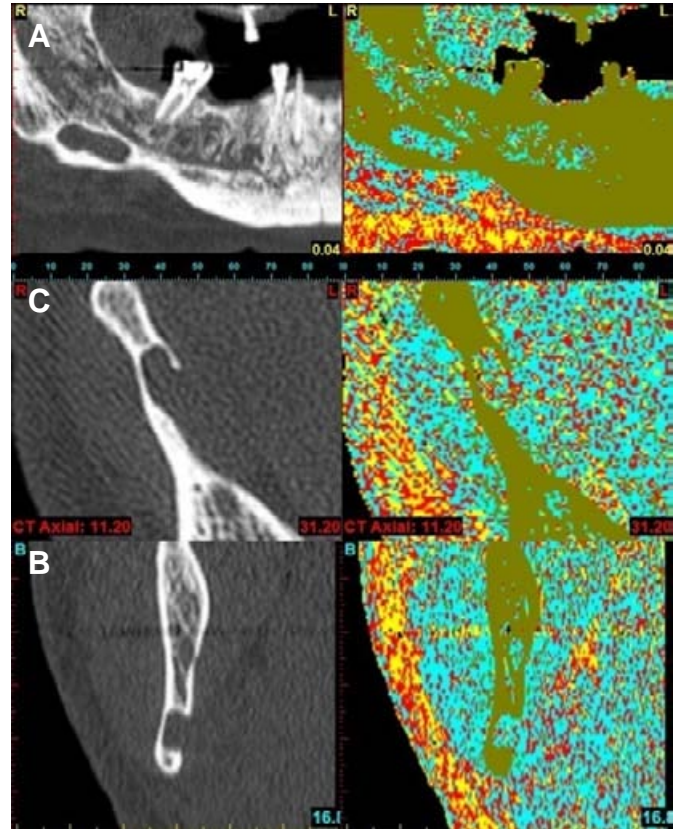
Colorful segmentation and differentiation of the defect by means of CT density color scale. This color scale places four colors next to each other, representing the different types of tissue. The density scale is based on the relation between ranges of Hounsfield Units and the different tissue types which is demonstrated in panoramic (A), axial (B) and sagittal images (C).
